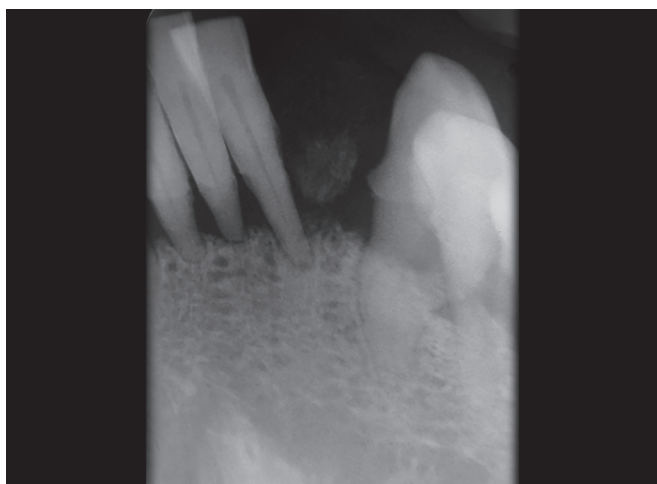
Intraoral periapical radiograph showing diffused radiopaque foci
